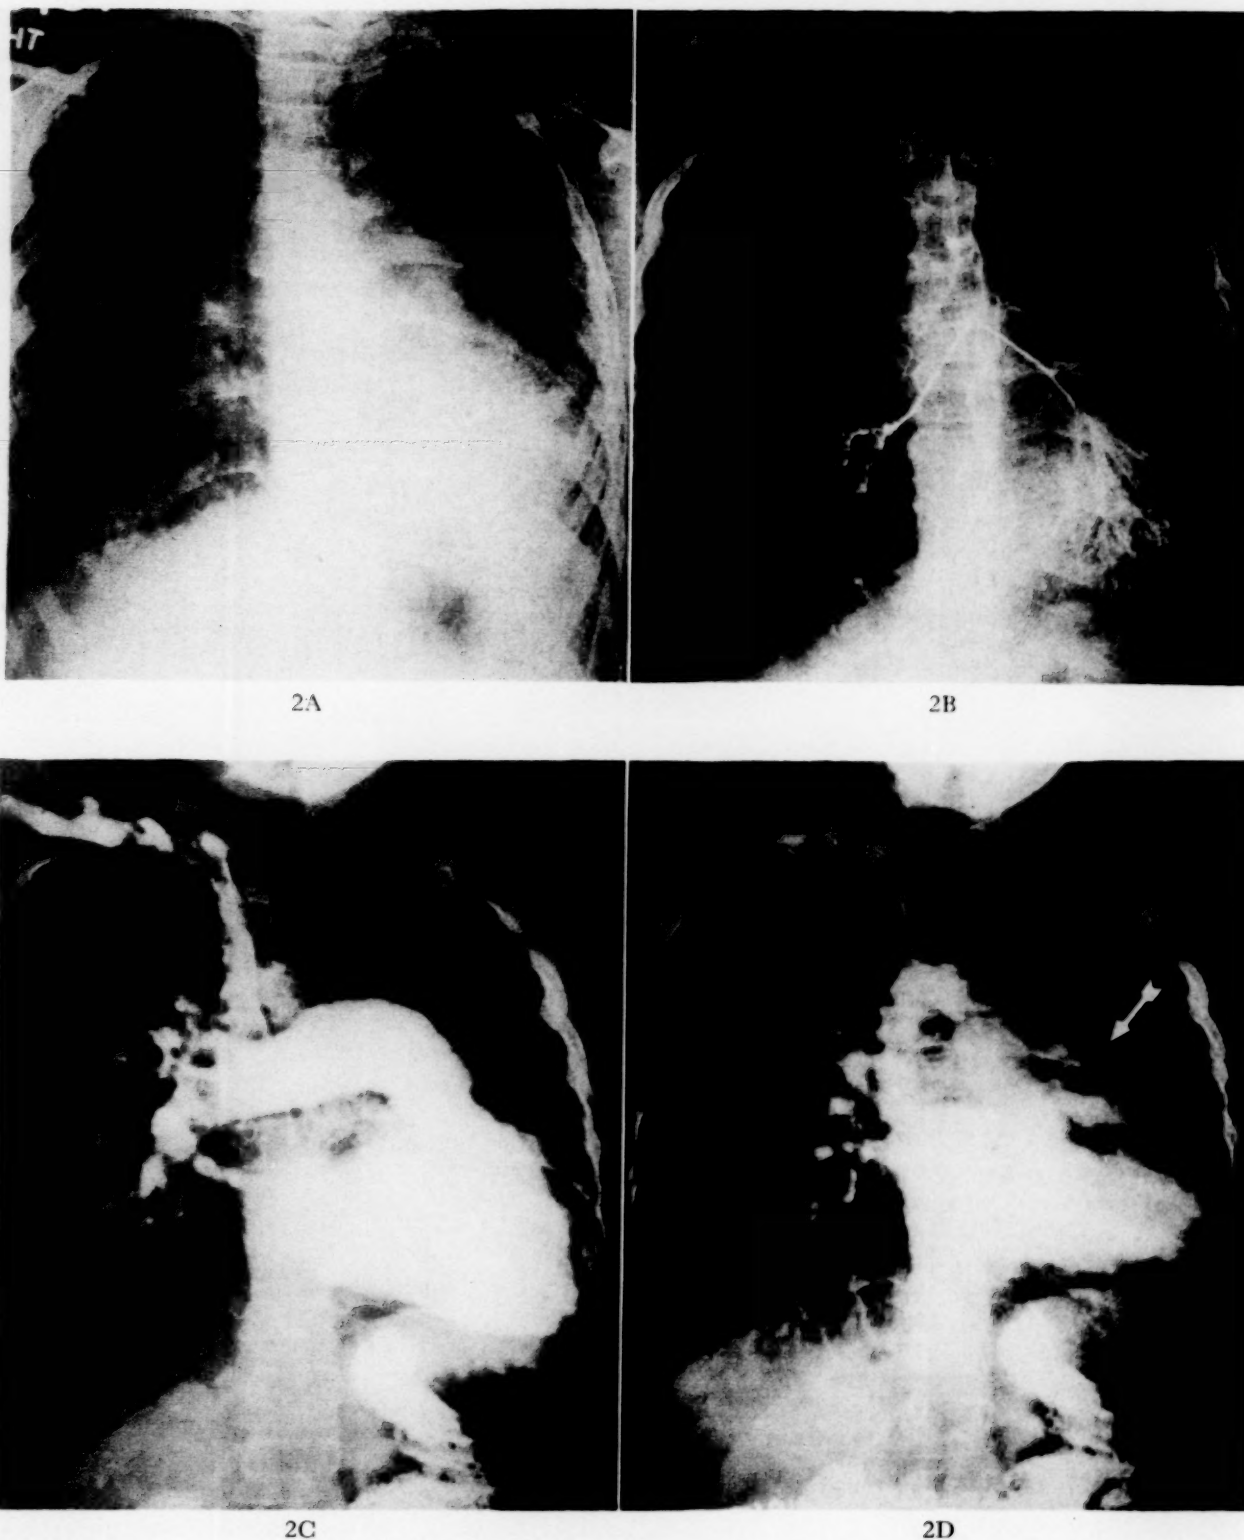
to D. CASE II. A, frontal roentgenogram shows enlargement and rotation of heart and mediastinum into left hemithorax. There is plethora of the right pulmonary vasculature; the left lung pulmonary arterial circulation is absent. B, frontal bronchogram shows hypoplasia, crowding and distortion of the left lower bronchial tree. The right bronchus, although inadequately filled, is normal. C, frontal angiocardigram reveals rotation of the heart in a right oblique fashion; there is absence of the left pulmonary artery. The right pulmonary artery and branches are enlarged. D, when the left side of the heart is opacified, the aorta is right-sided, the innominate artery is on the left and the common carotid and subclavian arteries are on the right side of the body. Persistence of right pulmonary arterial opacification (arrow) is due to a cardiac shunt.
